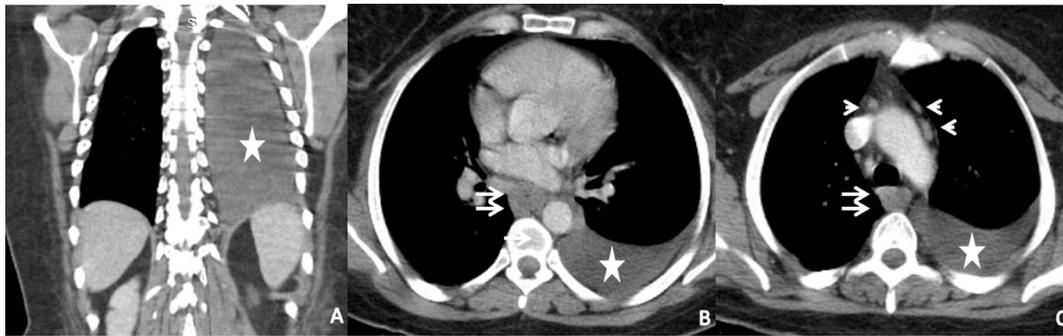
Computed tomography of the thorax shows left-sided pleural effusion (star) (A-C), esophageal wall thickening (white arrows) (B, C), and enlarged mediastinal lymph nodes around the aortic arc (arrowheads) (C).
